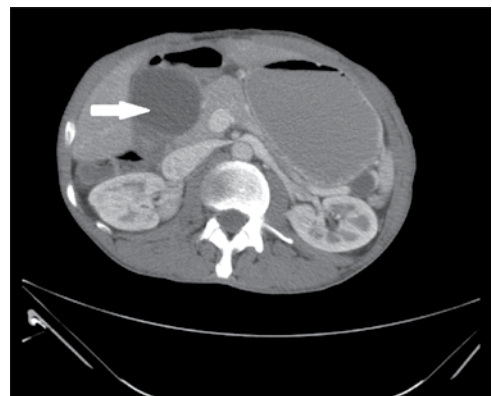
CT abdomen scan; the arrow shows a paraduodenal cystic lesion.
